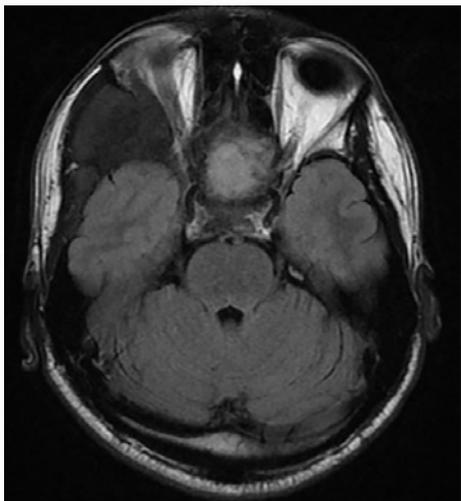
Postoperative FLAIR MRI sequence showing the complete evacuation of the mucocele in the sphenoid sinus. It also shows an improvement in the left optic nerve compression.
